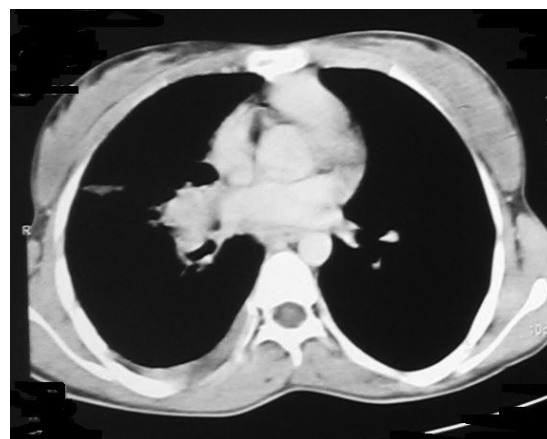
Chest CT-scan of the patient before chemotherapy
